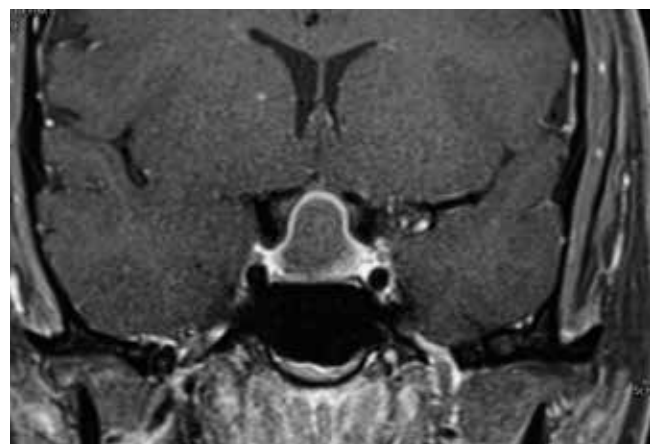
Contrast enhanced T1-weighted coronal magnetic resonance (MR) image showing pituitary lesion with peripheral enhancement.
